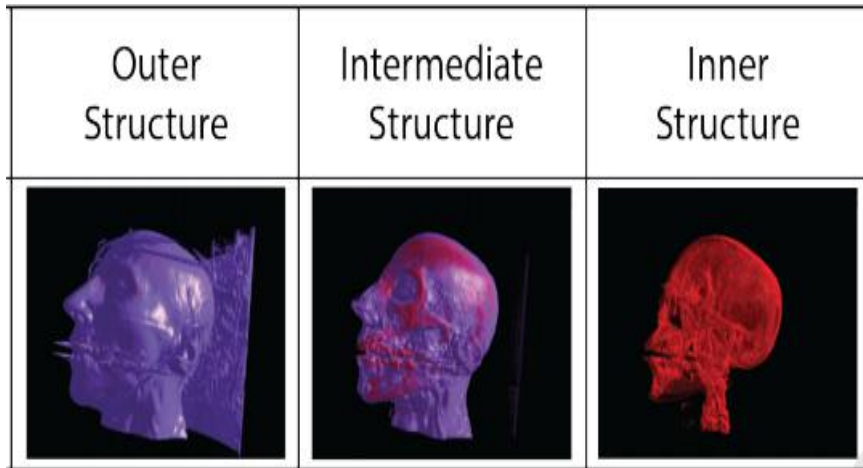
9 Brain CT volume rendering image
